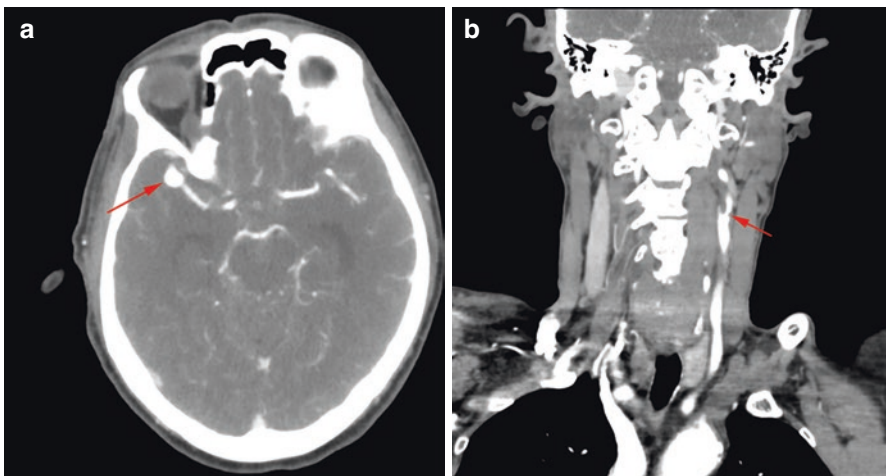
Computed tomography angiography demonstrating (a) right middle cerebral artery aneurysm (*arrow*) and (b) left internal carotid artery luminal stenosis (*arrow*). (© LS Ediriwickrema 2020. All Rights Reserved)
